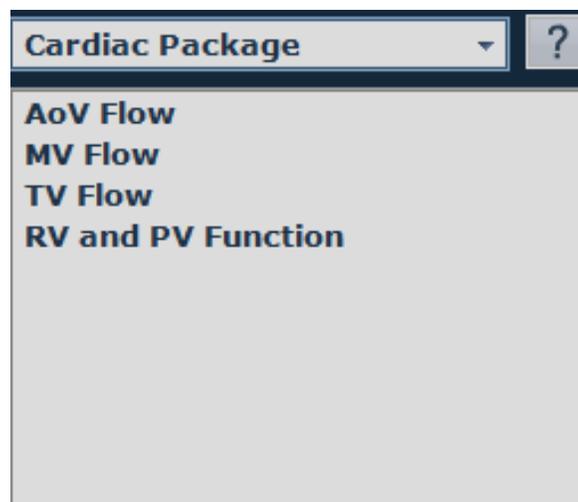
PW Doppler Cardiac package with the list of available protocols
